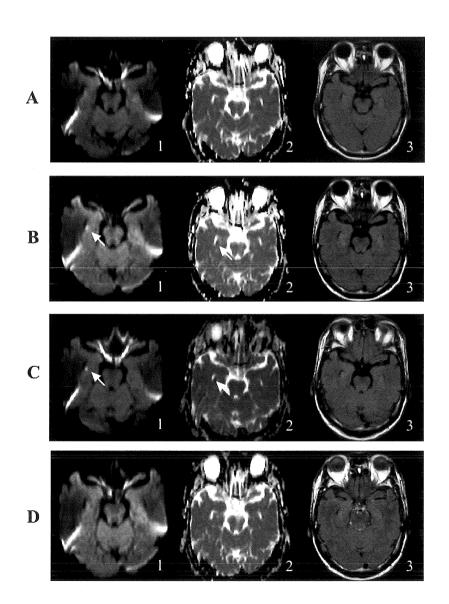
MR images from a patient with TGA (Patient 1) obtained 2 hr after onset (A-1, 2, 3). Diffusion-weighted image (DWI) (echo-planar spinecho sequence; b = 1000 sec/mm2) (A-1), apparent diffusion coefficient (ADC) map (A-2) and fluid-attenuated inversion recovery (FLAIR) image (A-3) were normal. After 25 hr, a hyperintense lesion was observed in the right parahippocampal gyrus on a DW image (B-1 arrow), while the same region showed low intensity on an ADC map (B-2 arrow). Hyperintensity on a DW image (C-1) and reduced ADC values (C-2) remained after 4 days. After 10 days, the lesion had disappeared on a DW image (D-1) and ADC map (D-2). No abnormality was noted on a FLAIR image in the corresponding region (D-3).
